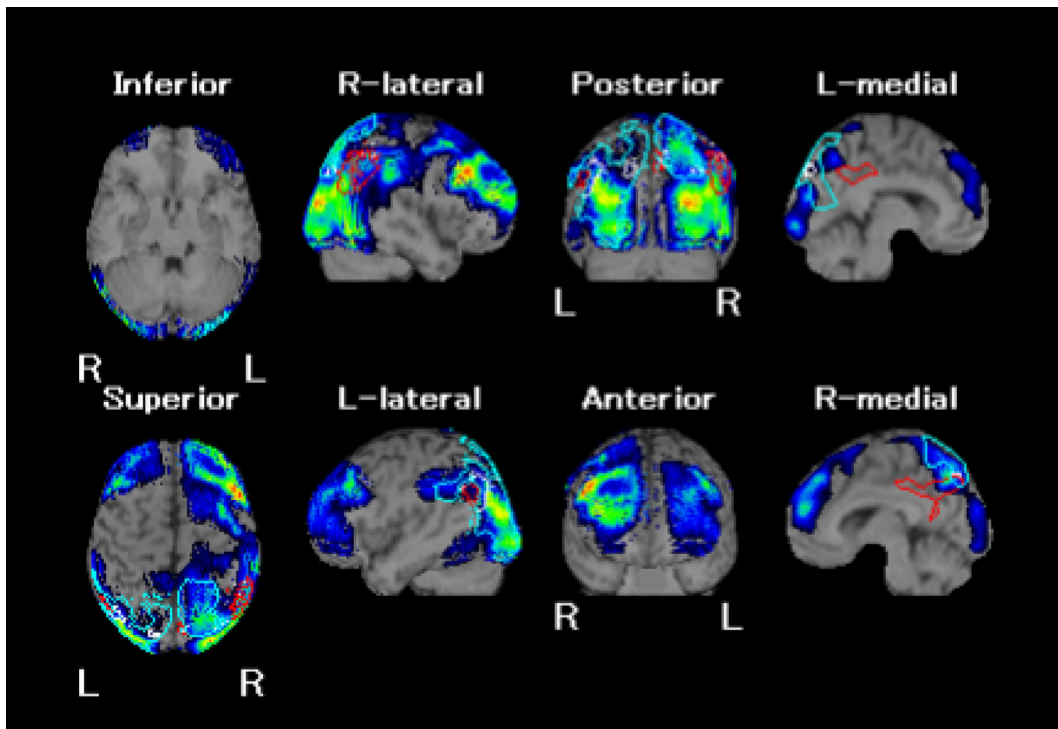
^{99m}Tc -ethyl-cysteinate dimer single-photon emission computed tomography (SPECT). SPECT images, analyzed with an easy Z-score imaging system, showed a decrease in the blood flow in the bilateral frontal, parietal, and occipital lobes and a posterior lesion of the temporal lobe. Overall, perfusion was decreased more on the right side than on the left side.
